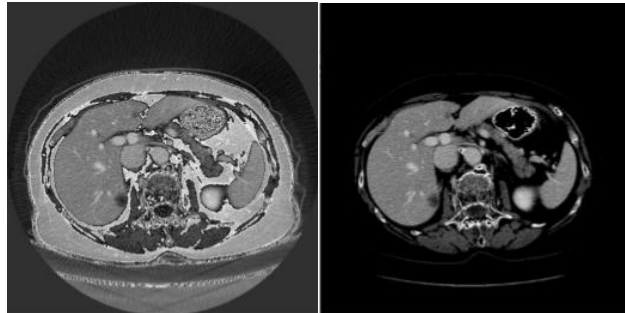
The effect of the preprocessing step on the CT scan image.
